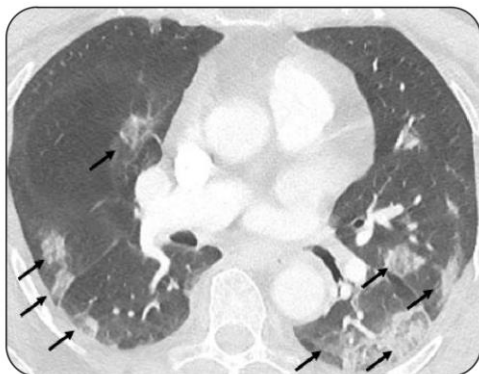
Lung window of chest CT scan showing multiple bilateral ground glass opacities.
